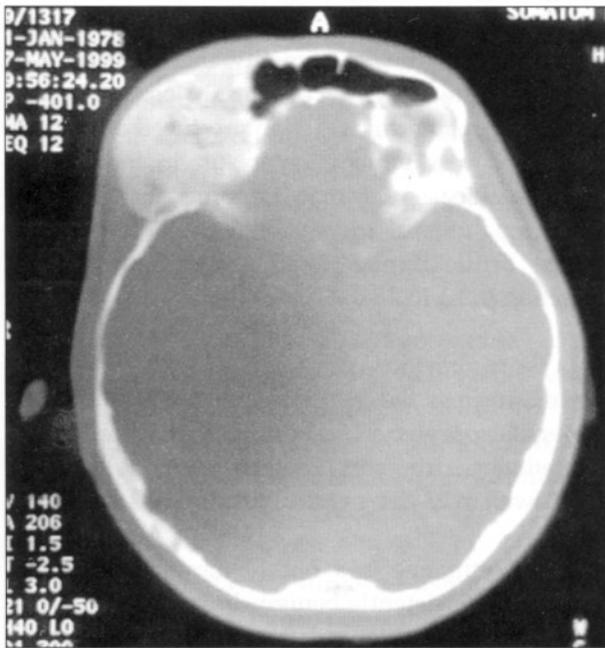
Preoperative axial (a) and coronal (b) computed tomography scans of the patient with fronto-orbital fibrous dysplasia.
